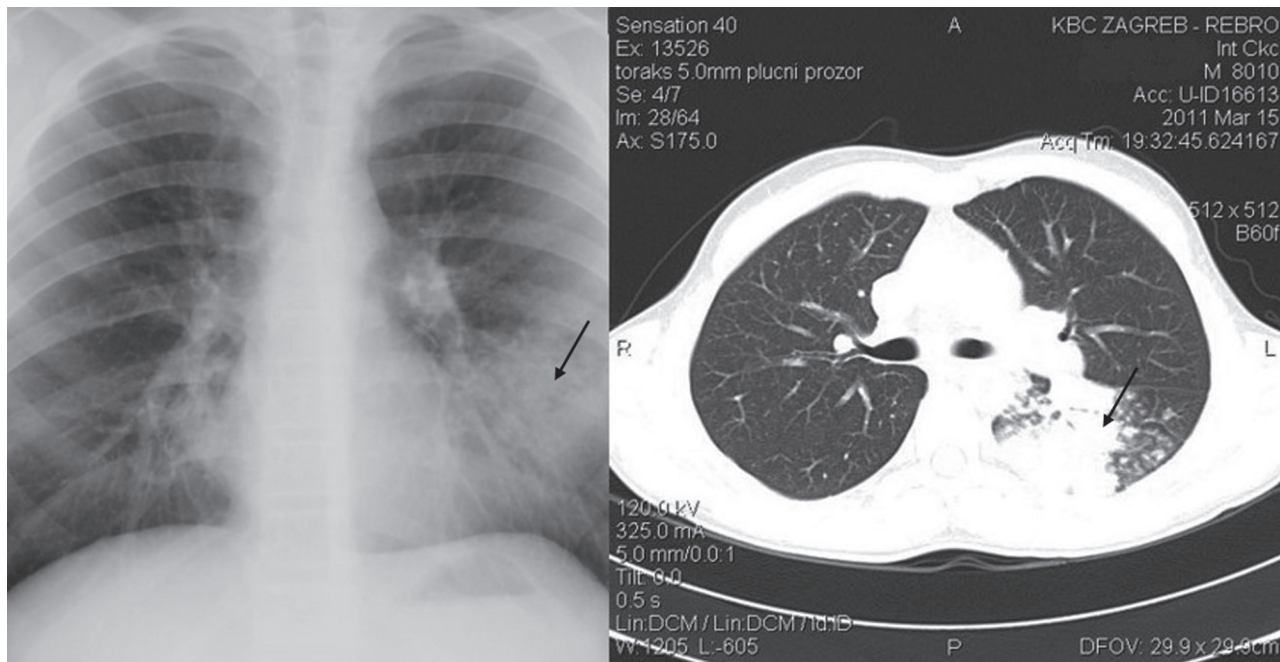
Radiological evaluation. A) The signs of left lower lobe consolidation and air bronchogram are consistent with pneumonia. B) Computed tomography scan confirmed an inflammatory infiltrate in the apical segment of the left lower lobe of the lung without signs of tissue destruction.
